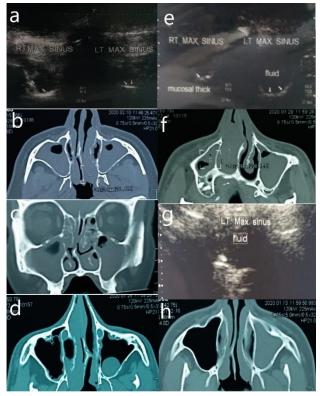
(a) US with posterior enhancement, (b) & (c) CT scan axial and coronal view of same case confirmed maxillary sinusitis, (d) CT scan axial view showing polypoidal lesion in Left maxillary sinus, (e) US scan shows mucosal thickening and debris in Right maxillary sinus & fluid level in left maxillary sinus with bright echoes posteriorly and (f) CT scan axial view of same case shows bilateral maxillary sinusitis, (g) US with bright echoes in left maxillary sinus while (h) CT scan confirmed maxillary sinusitis.
